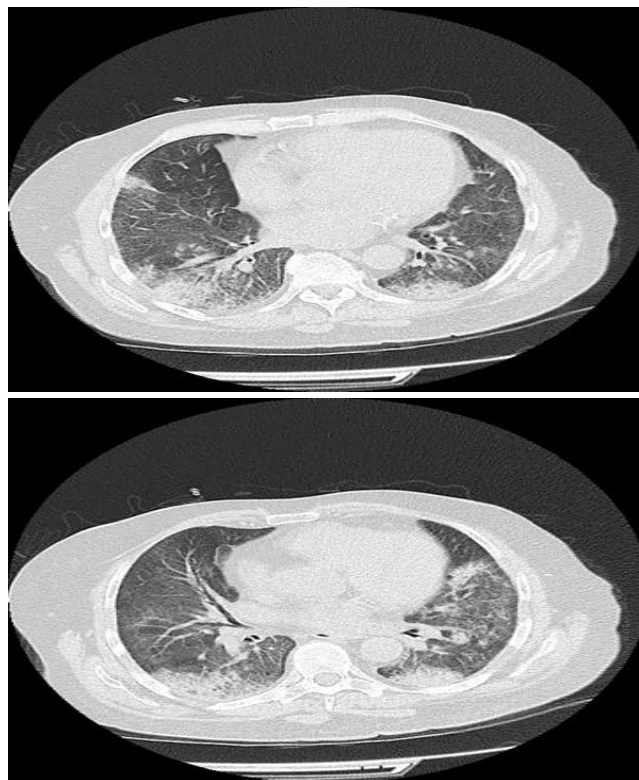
CT Chest of patient.
